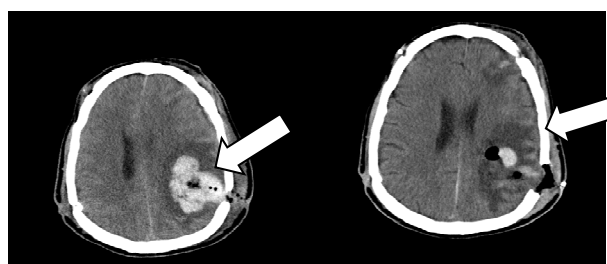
CT without contrast after fall and evacuation (on right). Large left parietal operative site hemorrhage and extra axial blood collection with associated mass effect with herniation and hydrocephalus.
